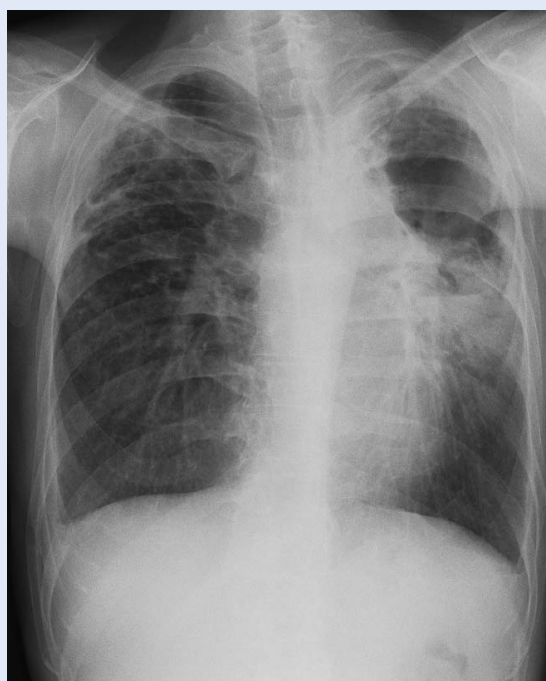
Chest radiograph (July 2017)
